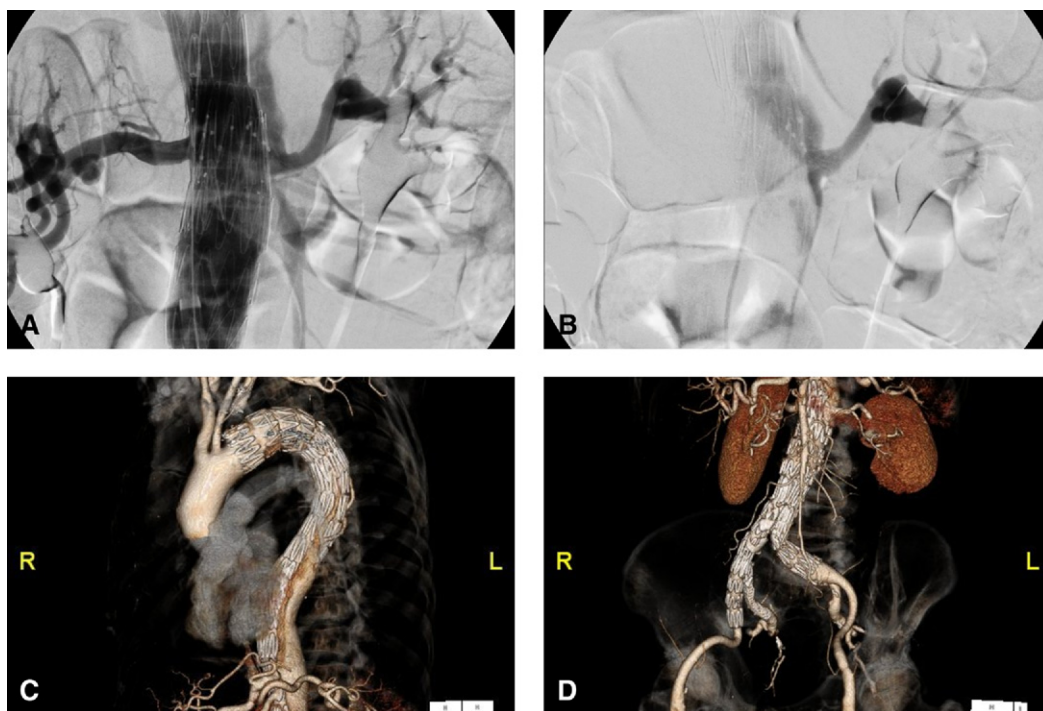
Intraprocedural angiogram that shows the supposed malperfusion of the left renal artery (LRA) arising from the false lumen after aortic stent placement (A) and LRA stented (B). Computed tomography (CT) scan at 10 days showing the occlusion of the entry tear and the collapse of the false lumen (C) and the exclusion of iliac aneurysm (D).
